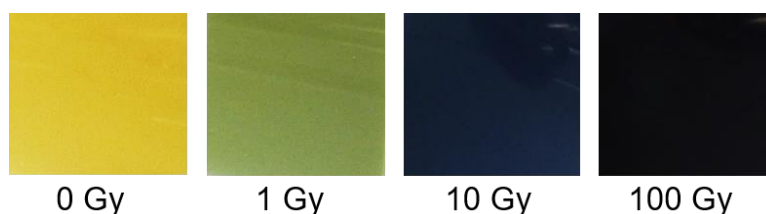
Photographs of Gafchromic EBT3 films that have been irradiated with increasing doses of X-rays, ranging from 1 Gy to 100 Gy.
